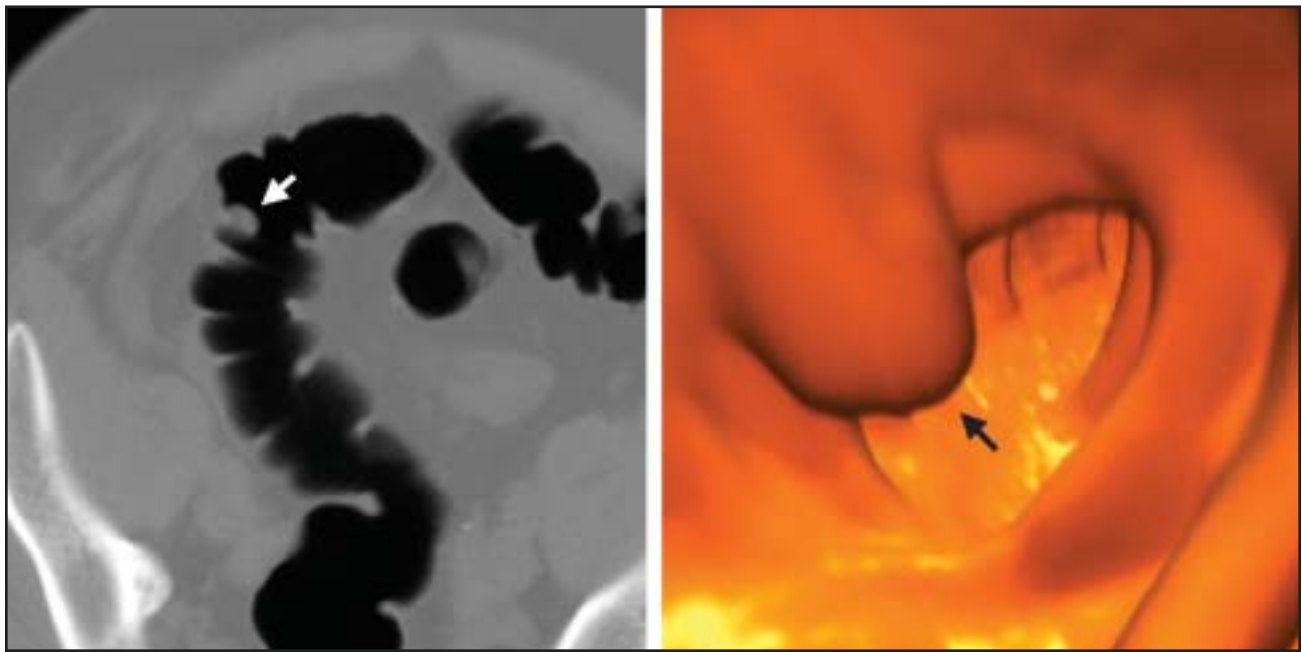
Two-dimensional image (left) of a 10-mm colon polyp (arrow) generated by a spiral computed tomography scanner, and reconstruction of a three-dimensional image of the polyp (arrow) viewed from within the lumen (right). Image courtesy of Viatronix Inc.
